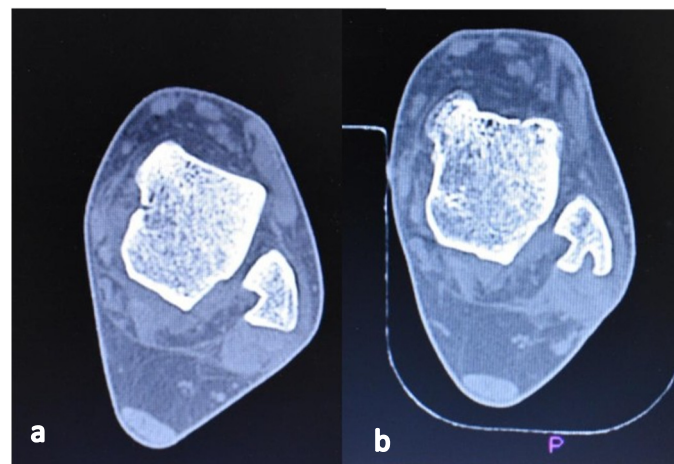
CT scan of a 28-year-old male. (a) Preoperative view that demonstrates a flat groove; (b) post-operative view with the DRG and a concave retromalleolar groove.
